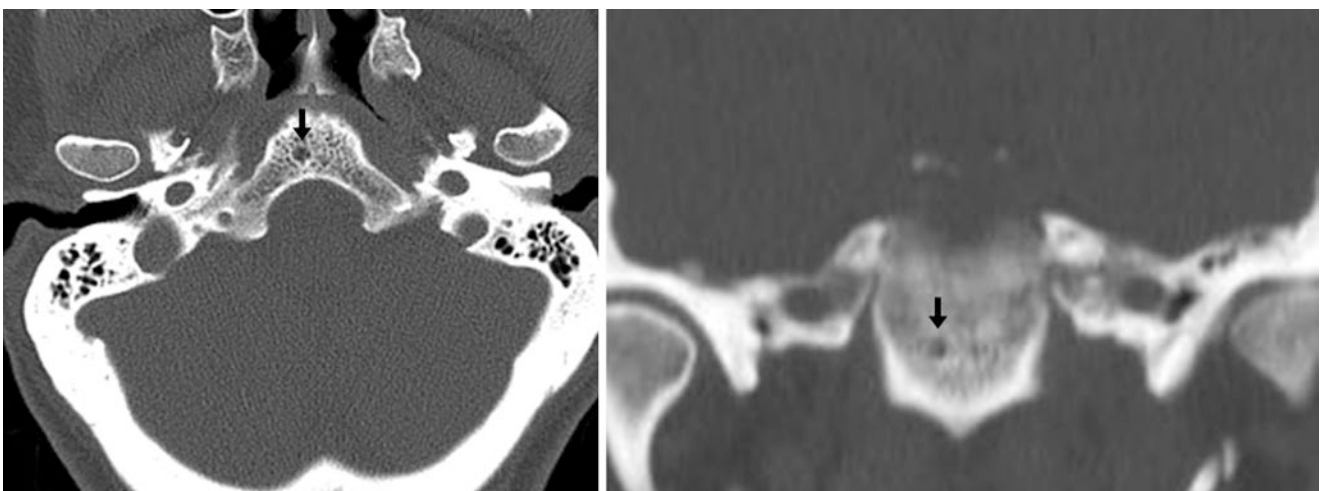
A 58 year old in whom on CT a tiny focus of fat density (−40 HU) within the basiocciput (*arrows*) was noted on axial (*left*) and coronal (*right*) reconstructions, consistent with arrested pneumatization
